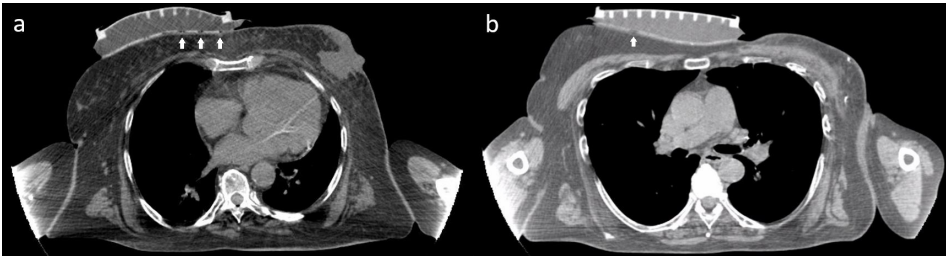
CT-scans show the conformity of (a) the thermocouple matrix and (b) the stretchable printed circuit board (SPCB) to the bodies of two different patients with locoregional recurrent breast cancer. The white arrows indicate the location of small air bubbles.
